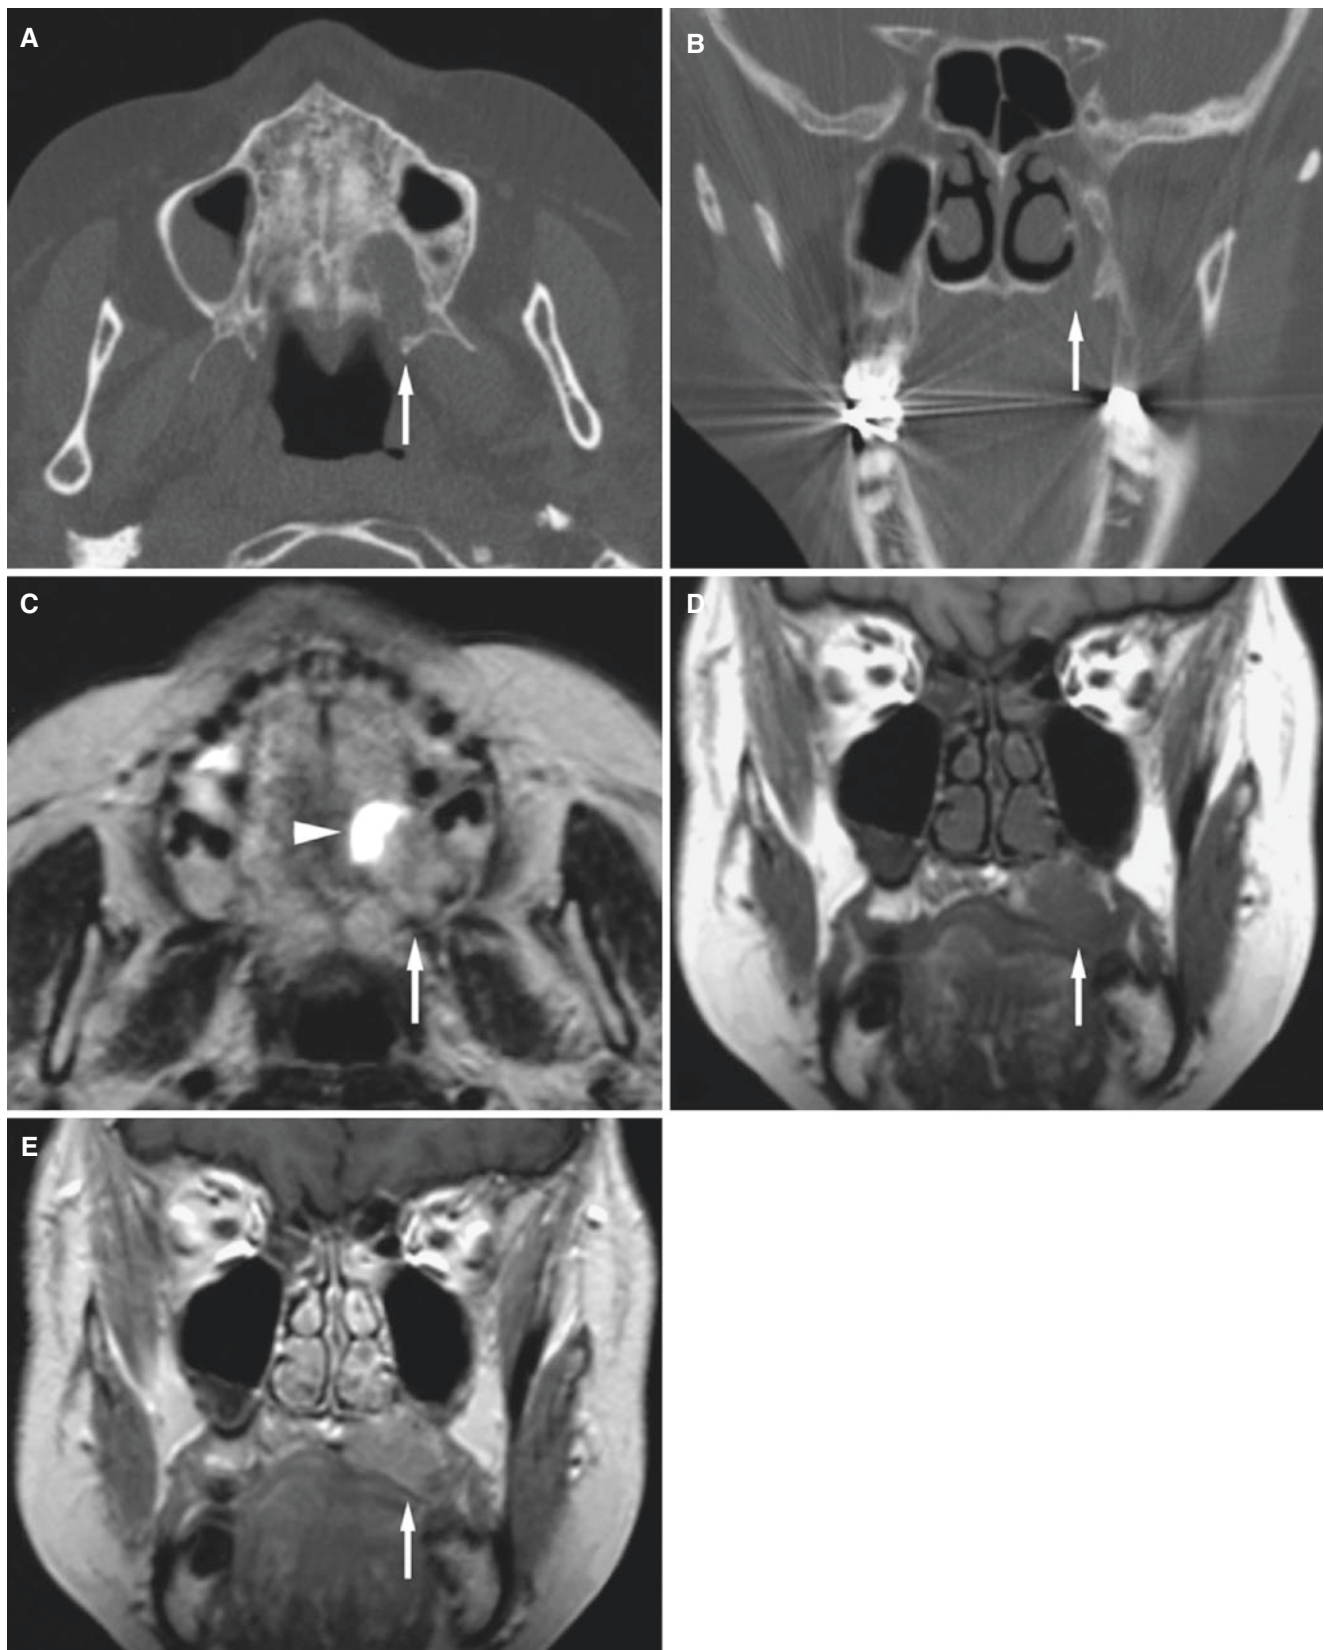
Adenoid cystic carcinoma, maxilla; 70-year-old female with painless swelling in the hard palate; aspiration from soft part showed “fluid.” (A) Axial CT image shows destruction in the hard palate (arrow). (B) Coronal CT image shows widened major palatine foramen and pterygopalatine fissure (arrow). (C) Axial T2-weighted MRI shows
